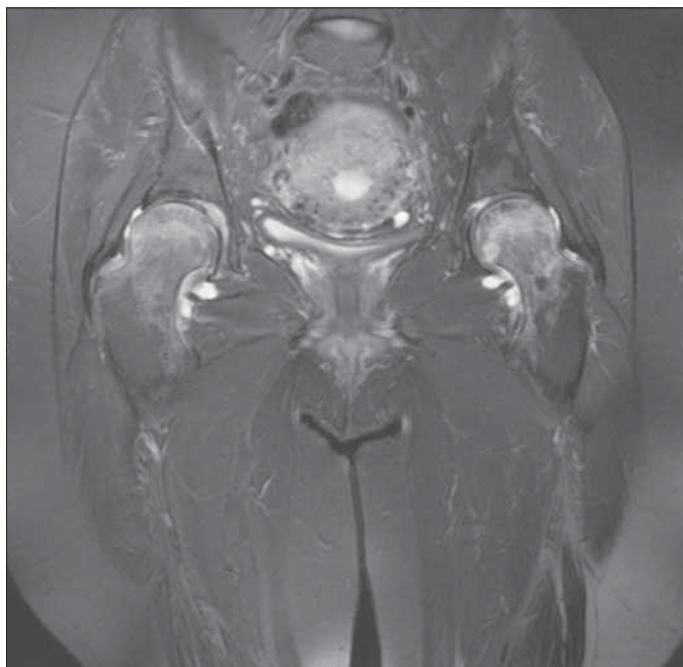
T2 weighted MRI demonstrates bone marrow edema in the femur head and neck and increased synovial fluid in the hip junction
